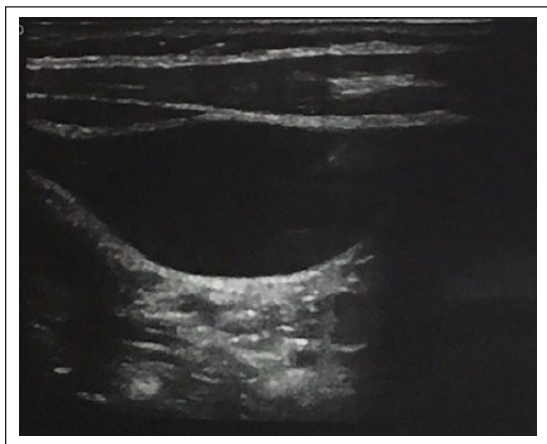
Doppler ultrasound of the right internal jugular vein on 1-year follow-up showing patent vein with the same diameter compared to previous CT and no thrombus formation.
